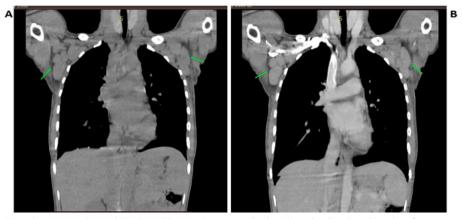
Noncontrast (A) and contrast-enhanced (B) chest CT scans showing multiple enlarged axillary lymph nodes of varying sizes
